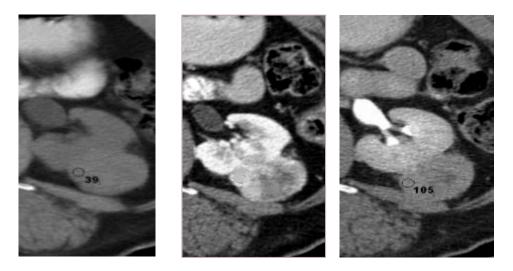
CT exam native and with contrast substance - nodular formation with tumor character
